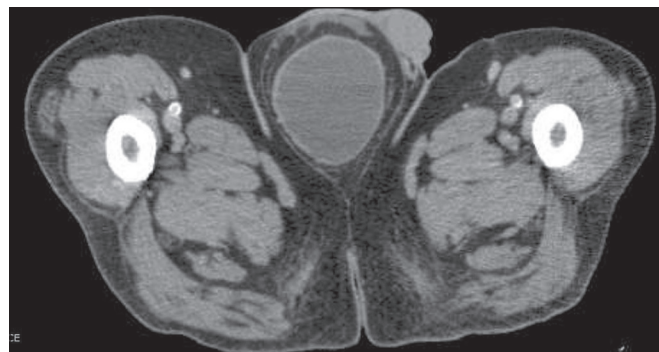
Axial CT scan of the pelvis showing the urinary bladder herniated into the scrotum.
